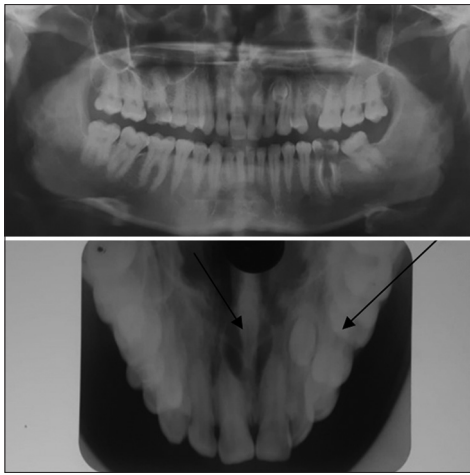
Orthopantomogram and Occlusal view shows the characteristic heart shaped radiolucency with radiopaque border at the apices of 11 and 21 and impacted supernumerary tooth
